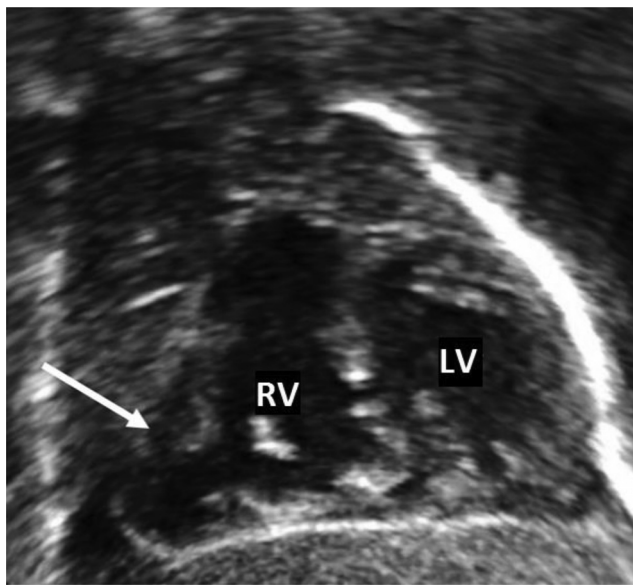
2D conventional transthoracic echocardiogram showing focal outpouching (arrow) of the right ventricle at the acute angle of the heart.
